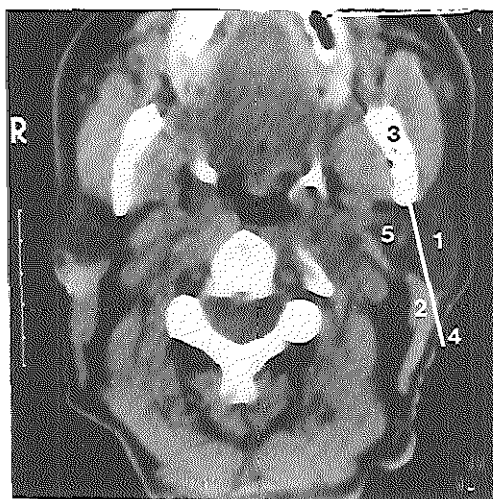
Transverse CT section at the level of the parotid gland in region II.
